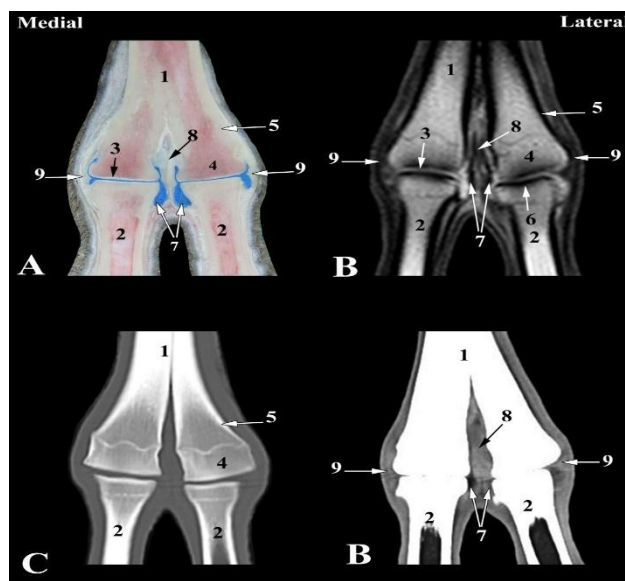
Dorsal images of fetlock joint of camel at the level of collateral ligaments attachment (Level 5 as indicated in Fig. 1). A- Dorsal anatomical section; B- Magnetic resonance image; C- Bone window computed tomography image; D- Soft tissue window computed tomography image: 1- Metacarpus; 2- Proximal phalanx; 3- Articular cartilage; 4- Cancellous bone; 5- Cortical bone; 6- Subchondral bone; 7- Joint cavity of fetlock joint; 8- Axial collateral ligaments of fetlock joint; 9- Abaxial collateral ligaments of fetlock joint.
